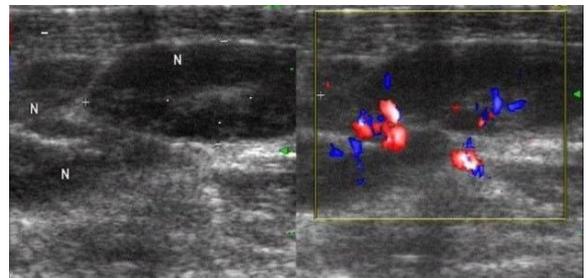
Reactive Lymphadenopathy: Ultrasound image showing well defined, oval homogeneously hypoechoic lymph nodes with hilar pattern of vascularity
